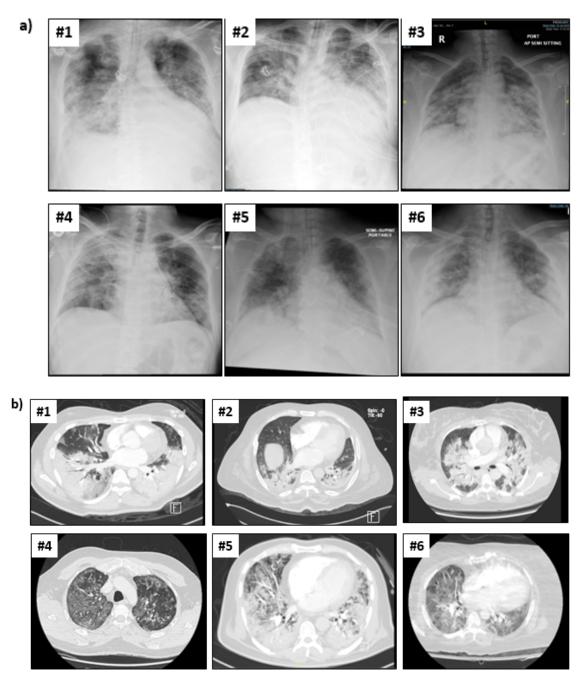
Radiological findings [chest X-ray (a) and CT (b)] on day of admission in Covid-19 patients: a) Portable chest X-ray and b) CT chest images in the lung view of representative cases at presentation showing extensive bilateral air space disease (#1, #2), consolidation (#3) and ground glass opacities (#4, #5, #6).
